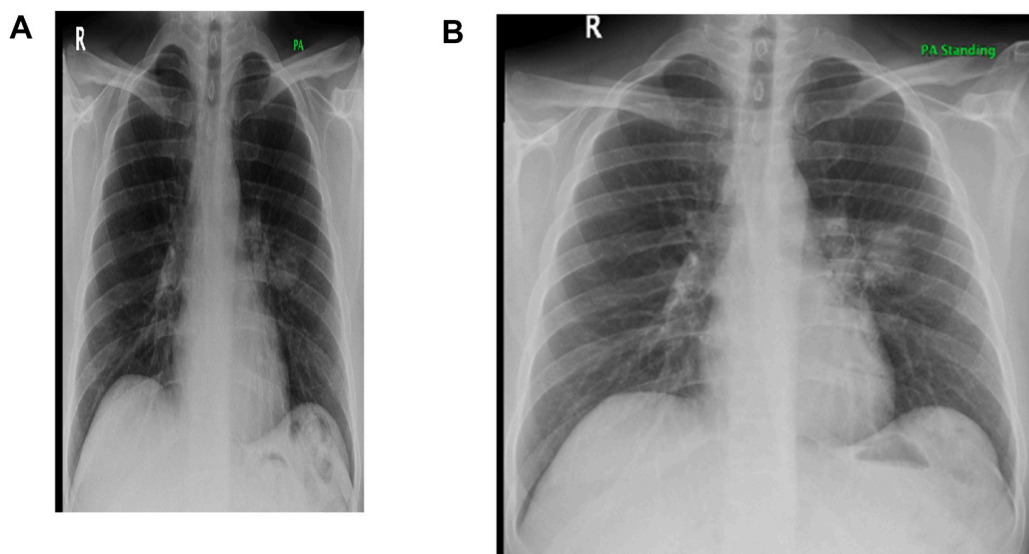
Chest x-ray posteroanterior view 23-August-2021: left paracardiac opacity with ill-defined margin and this appearance of the internal gas.
